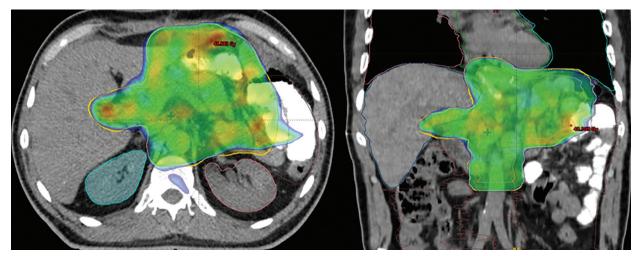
An IMRT treatment plan of one of our T4N1M0 gastric adenocarcinoma diagnosed patients after subtotal gastrectomy. (Left) Dose distribution on PTV covered by 95% of the prescribed dose in axial view of planning computed tomography; (Right) Dose distribution on PTV covered by 95% of the prescribed dose in coronal view of planning computed tomography
